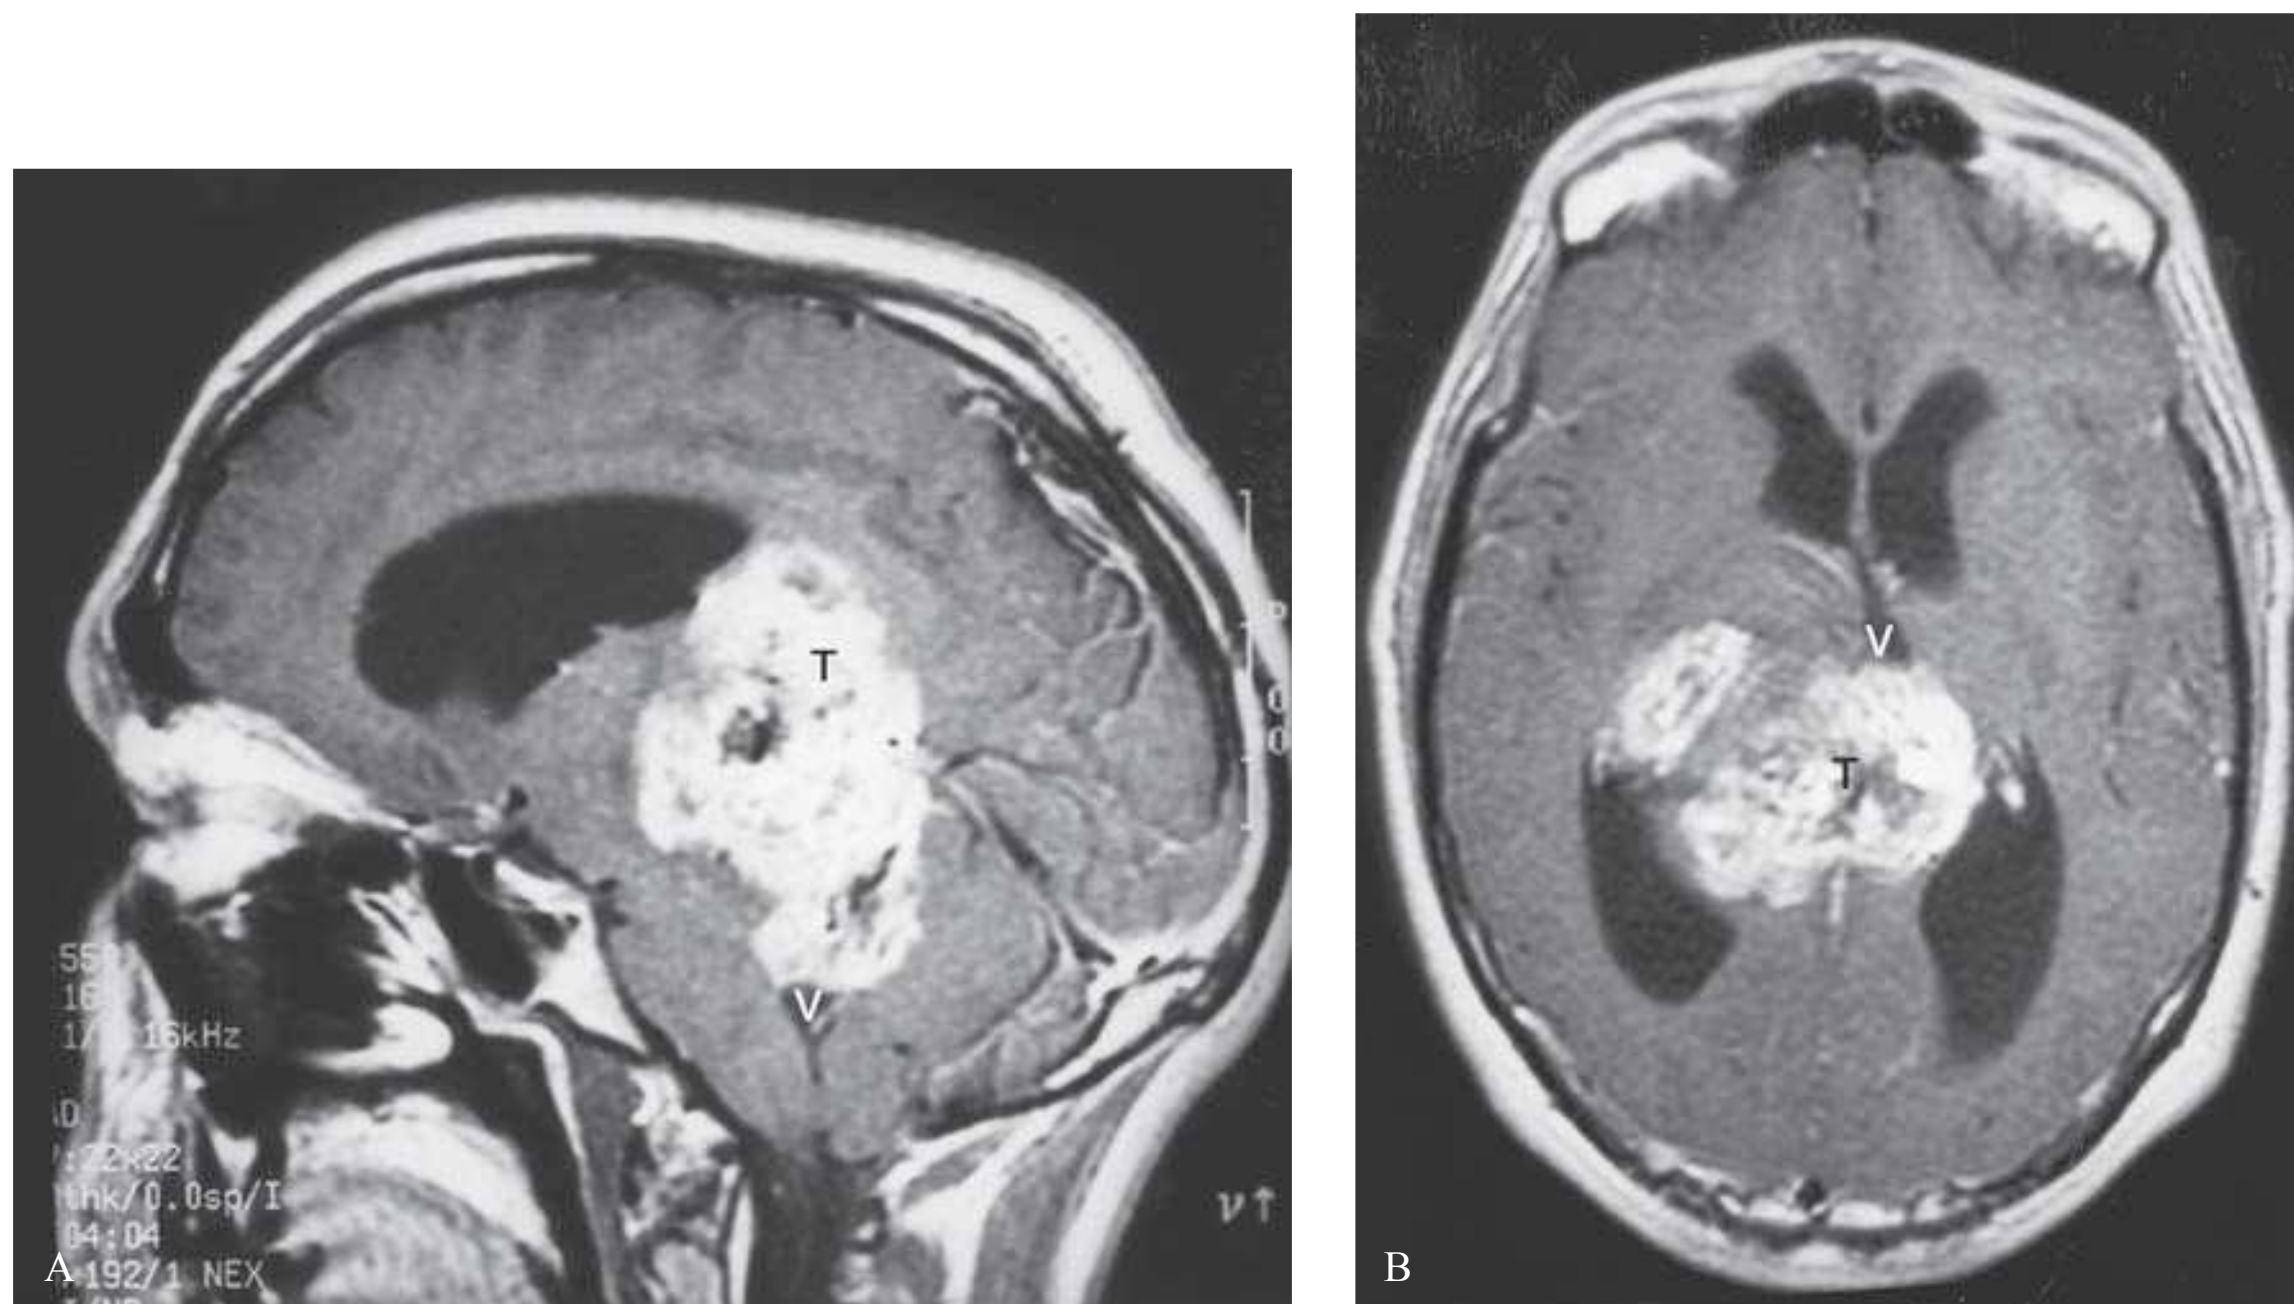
A: This sagittal magnetic resonance imaging on a patient with headache, lethargy, and diffuse weakness shows an enhancing mass (T) extending from the pineal region to the fourth ventricle (V). B: Axial views show the tumor (T) compressing the third ventricle (V) with hydrocephalus. Despite an aggressive surgical resection of this glioblastoma multiforme, the patient subsequently developed recurrent hydrocephalus and required a ventriculoperitoneal shunt.
